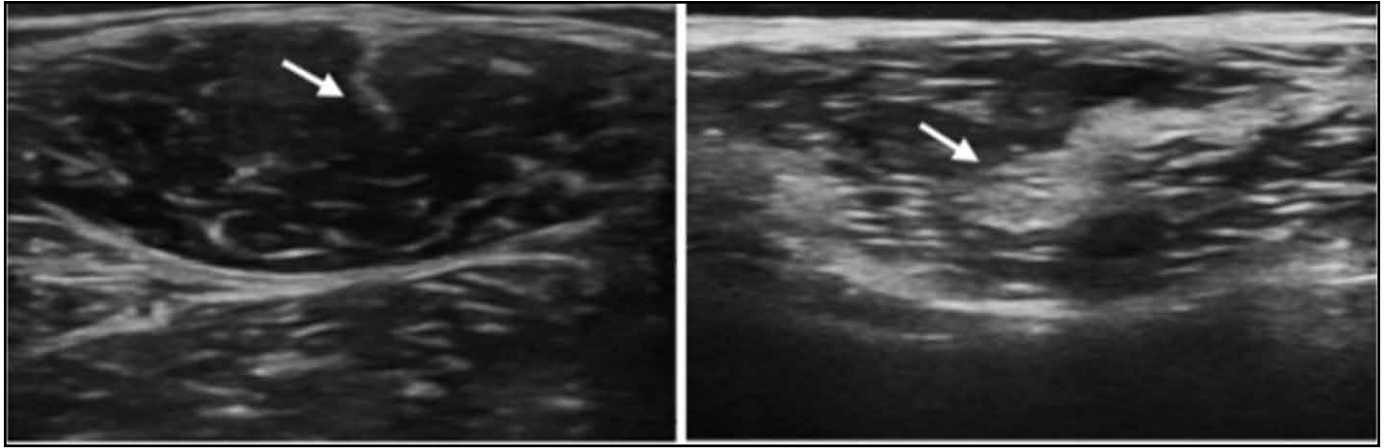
Ultrasound of rectus femoris in a normal individual (left) and a patient with Bethlem myopathy (right). Note the central fascial insertion (arrow) which is thin in the normal muscle and abnormally thickened in Bethlem myopathy.
